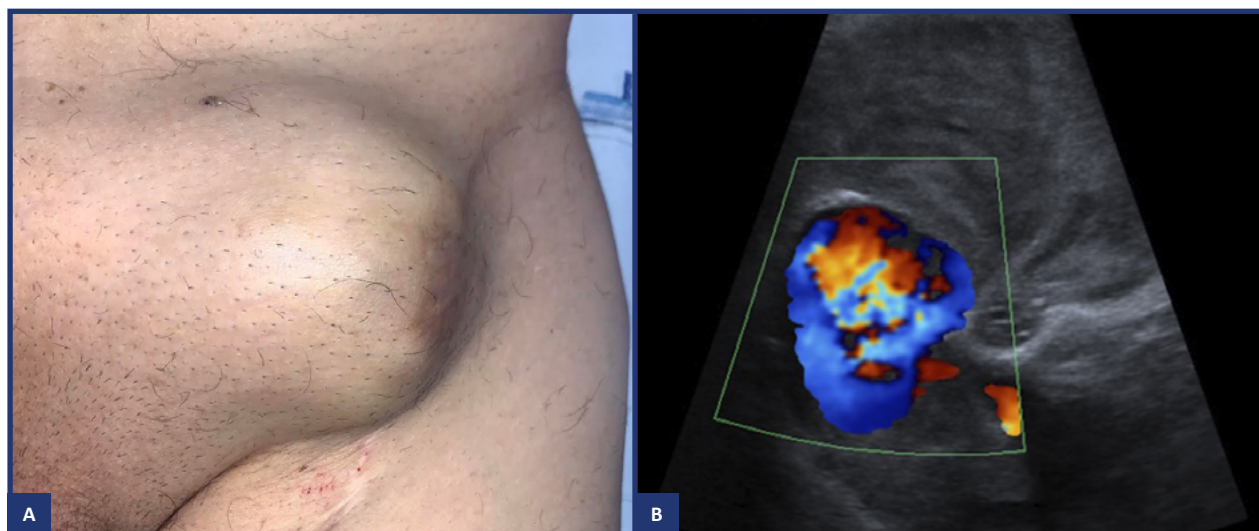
Left common femoral pseudoaneurysm, mass (A), and echo-Doppler (B).
